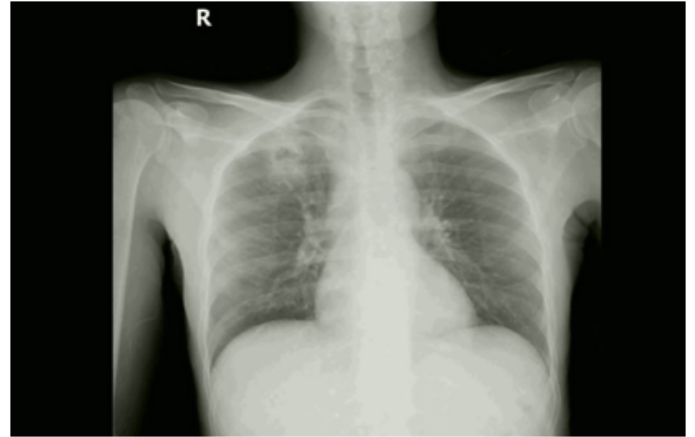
Chest x-ray showed right upper zone cavitating lung opacity
